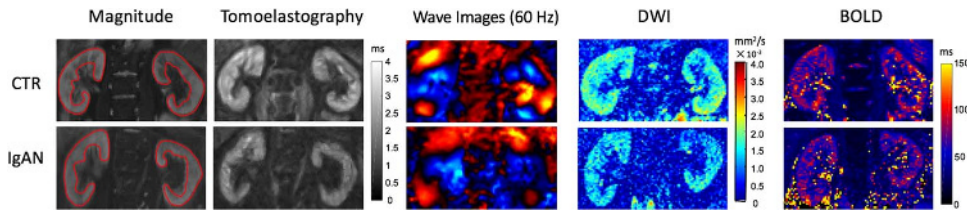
Magnitude images of the MRE scan, tomoelastography shear wave speed maps, wave images at 60 Hz, DWI, and BOLD imaging of a healthy control (CTR) and a patient with immunoglobulin A nephropathy (IgAN) and stage 2 chronic kidney disease (eGFR, 89–60 mL/min/1.73 m²). A marked decrease in SWS and ADC is visible in IgAN, whereas T2* values appear to be only marginally lower in IgAN. Representative regions of interest (ROIs) are demarcated for the entire renal parenchyma comprising cortical and medullar regions (red lines).
